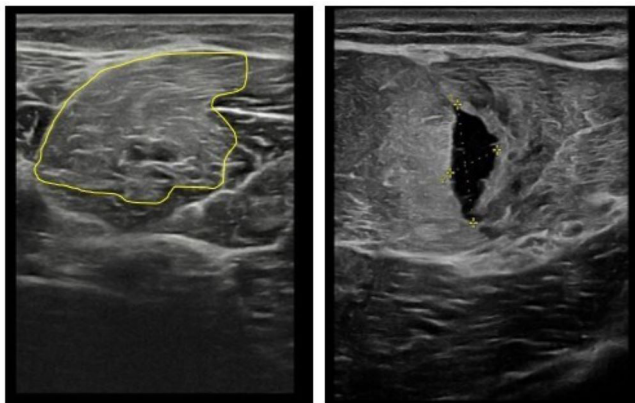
Ultrasound (US) presentation of two different biceps femoris injuries. First injury—left panel (transverse short-axis US scan over the sixth proximal hamstring region): non-structural lesion showing a hyperechoic area (highlighted in yellow), without evidence of fibre disruption, consistent with a functional muscle disorder. Second injury—right panel (transverse short-axis US scan over the sixth proximal hamstring region): structural lesion (type 3B muscle injury) demonstrating an anechoic area (outlined by yellow asterisks), indicative of an intramuscular haematoma due to disruption of muscle fibres.
